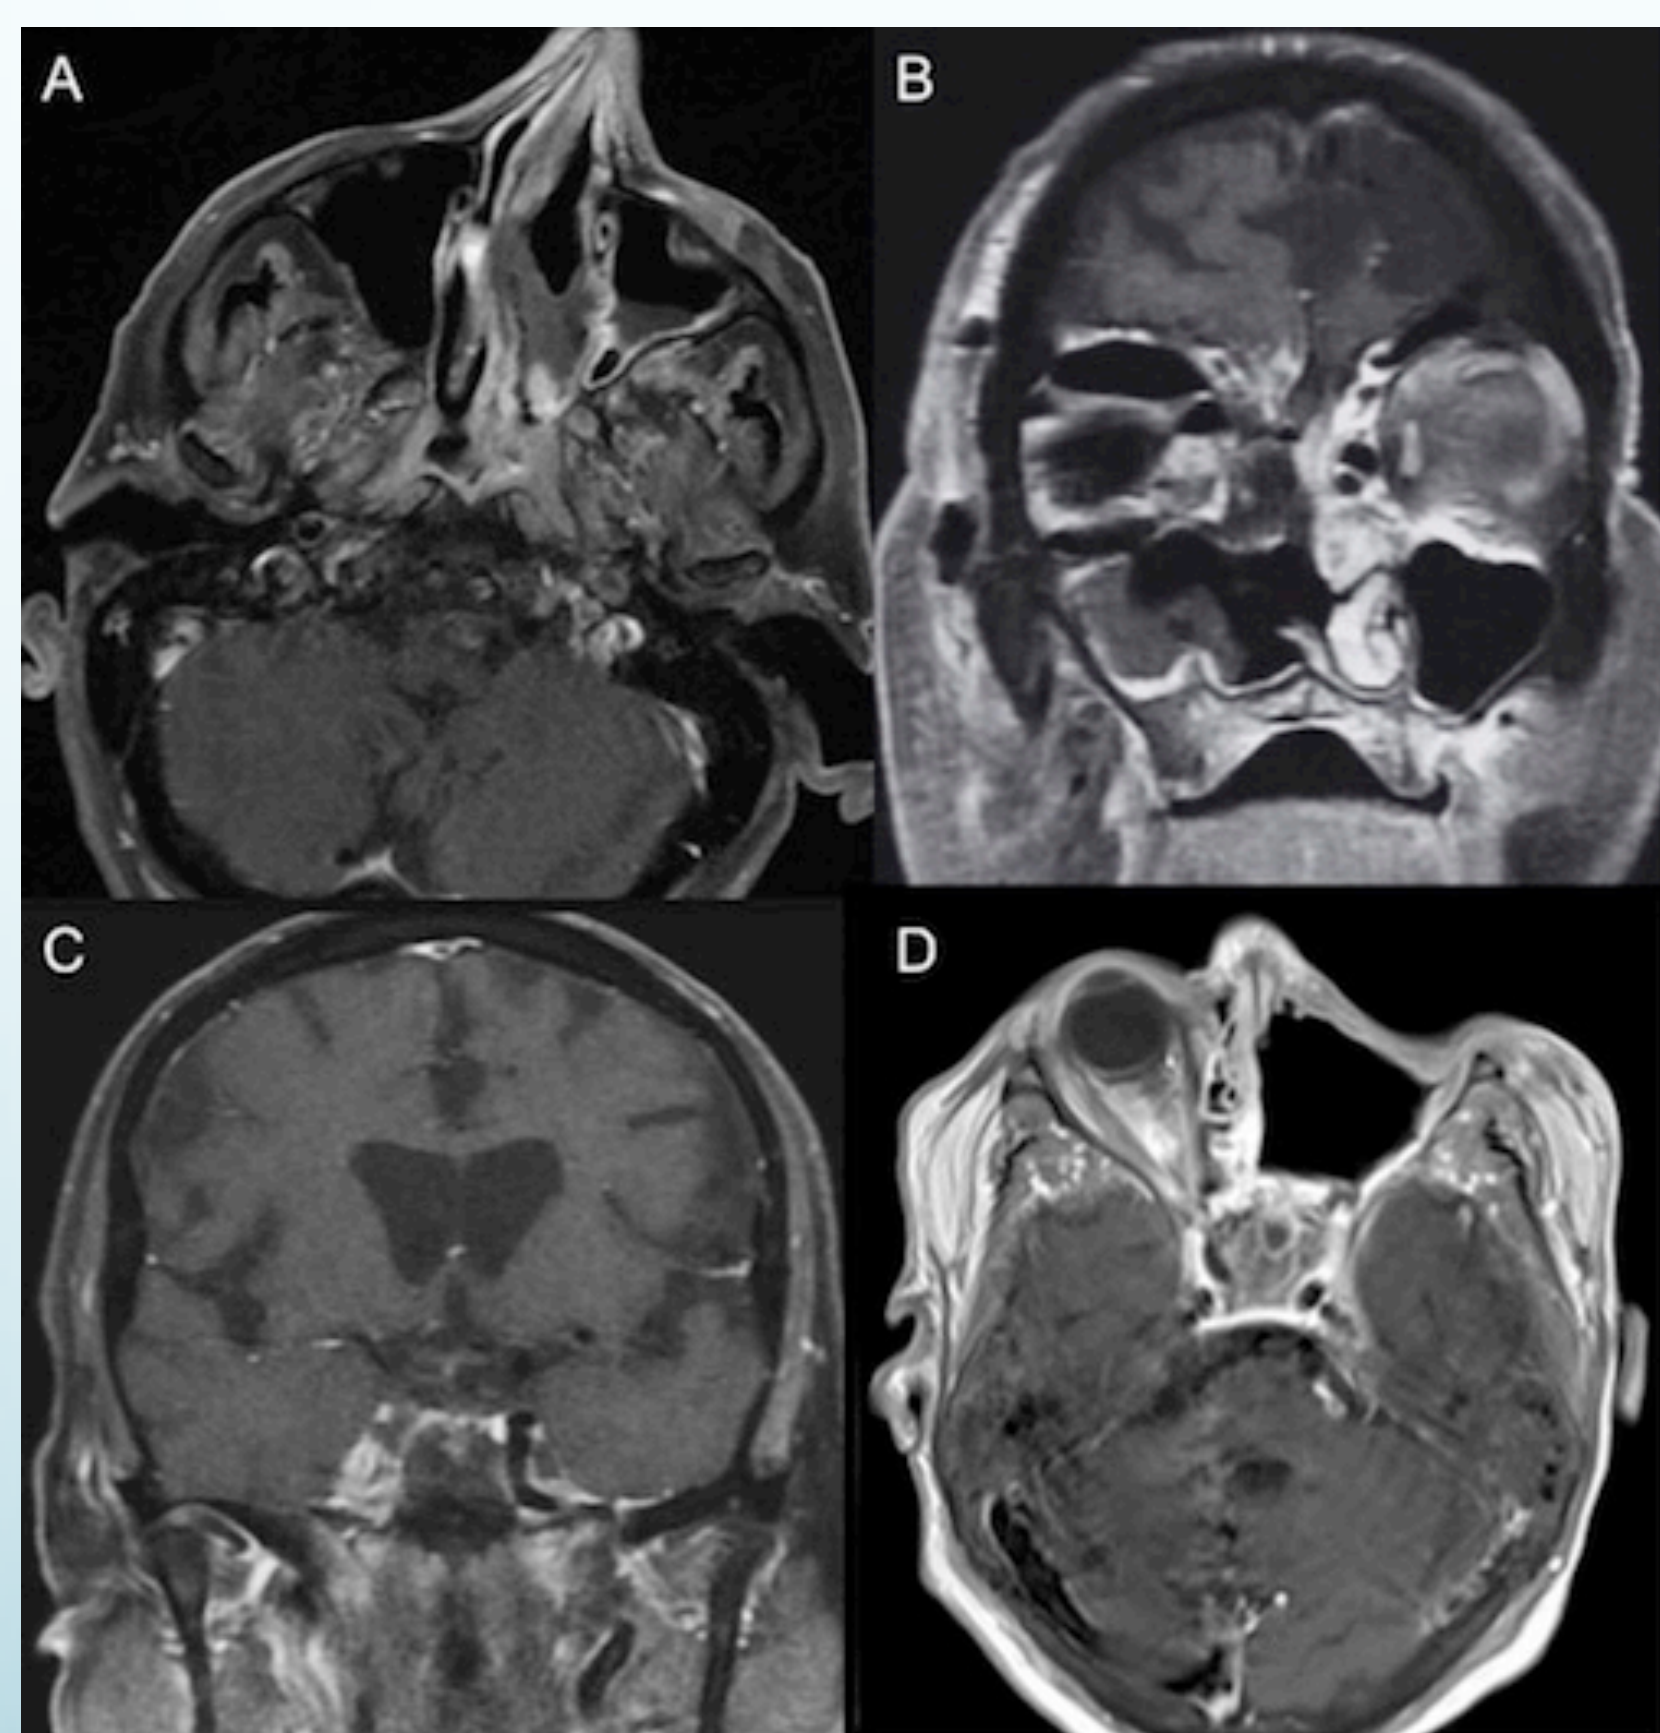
Axial and coronal T1-weighted, gadolinium enhanced, magnetic resonance imaging (MRI) showing (a-b) sinonasal and (c-d) cavernous sinus invasive fungal infiltration
